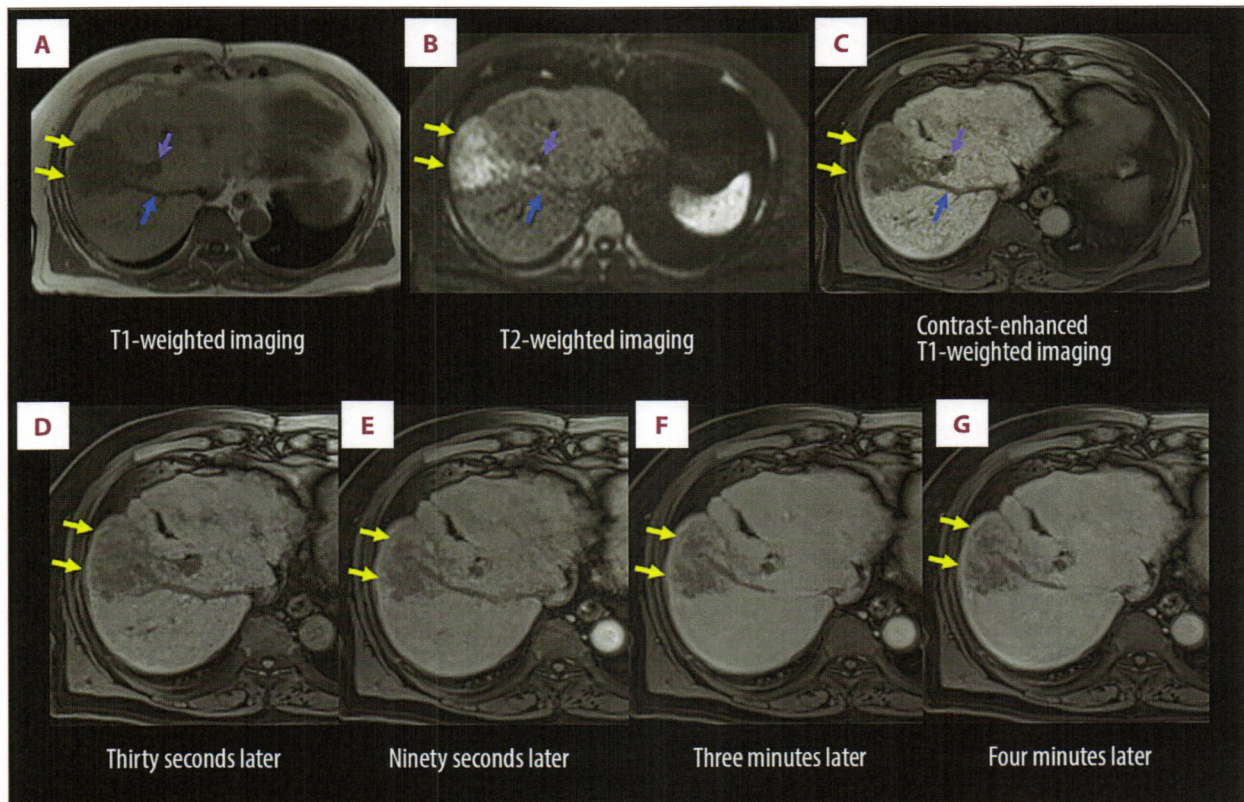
MRI findings 13 days after the initial diagnosis. The hepatic tumor had enlarged to 55 mm (yellow arrows), with tumor thromboses clearly observed in the right HV (A-C, blue arrows) and the anterior branch of the PV (A-C, purple arrows). The tumor appeared hypointense on T1-weighted imaging (A) and hyperintense on T2-weighted imaging (B). Contrast-enhanced T1-weighted imaging did not show any enhancement in the early phase (C). Gadoxetic acid-enhanced MRI at 0.5 (D), 1.5 (E), 3.0 (F), and 4.0 (G) minutes after injection did not reveal early wash-in or wash-out in the hepatic tumor. HV – hepatic vein; MRI – magnetic resonance imaging; PV – portal vein.
